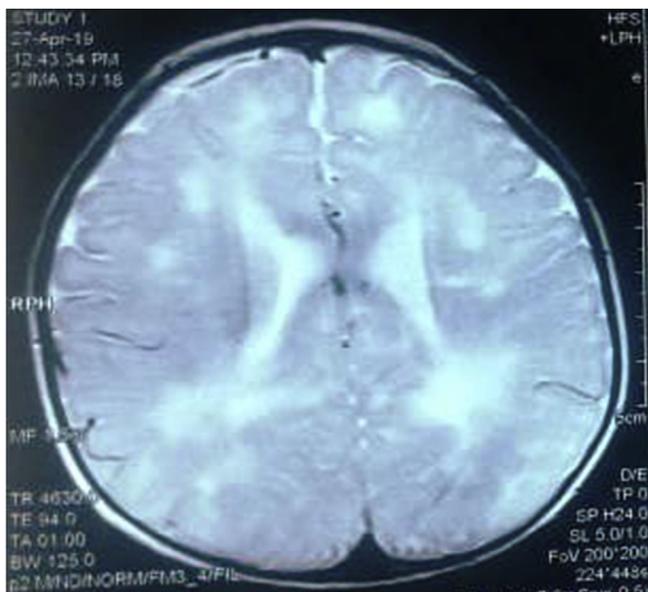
Axial T2 weighed MRI brain of the child showing bilateral periventricular white matter signal changes consistent with congenital rubella syndrome.
